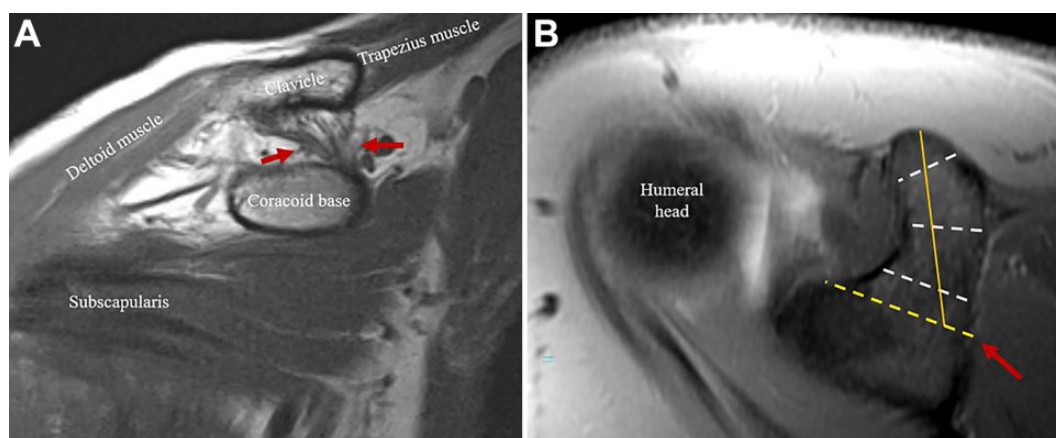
Demonstration of coracoid width measurements. (A) First, on the coronal oblique T1-weighted sequence, the coracoclavicular ligaments were identified (between the red arrows), outlined by fat, including the more lateral trapezoid ligament and medial conoid ligament. (B) Using scout localizers, the insertion of the coracoclavicular ligaments on the fluid-sensitive axial sequence was identified (red arrow). A line was drawn from this point to the anterior margin of the glenoid (yellow dotted line) denoting the width of the coracoid base. Coracoid width measurements were then collected at 3 locations: 5 mm anteriorly from the coracoid base, midpoint, and 5 mm posteriorly from the coracoid tip (white dotted lines). A straight line from the midpoint of the base to the tip (yellow solid line) was drawn to approximate coracoid length.
